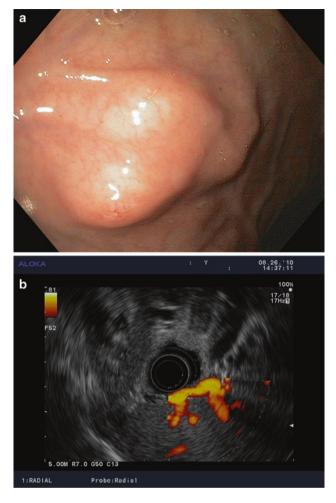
(a) Endoscopic view of extrinsic compression of the stomach. (b) Radial EUS image of prominant splenic vessels causing extrinsic compression. The use of color doppler confirms vessel flow.
